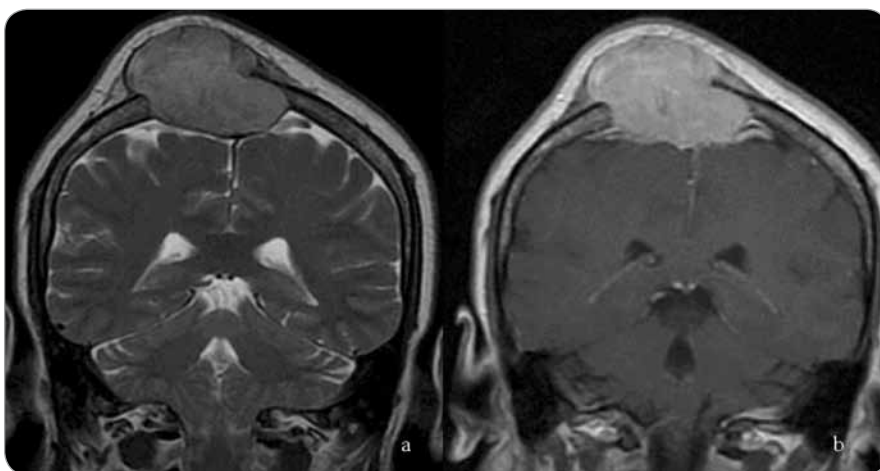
Coronal T2-weighted fast spin echo and sagittal contrast enhanced T1-weighted MRI images show a calvarial expansile lytic lesion located at the right paramedian frontoparietal region with an intense heterogeneous contrast enhancement. There is also compression and displacement of superior sagittal sinus without any finding of dural invasion.
